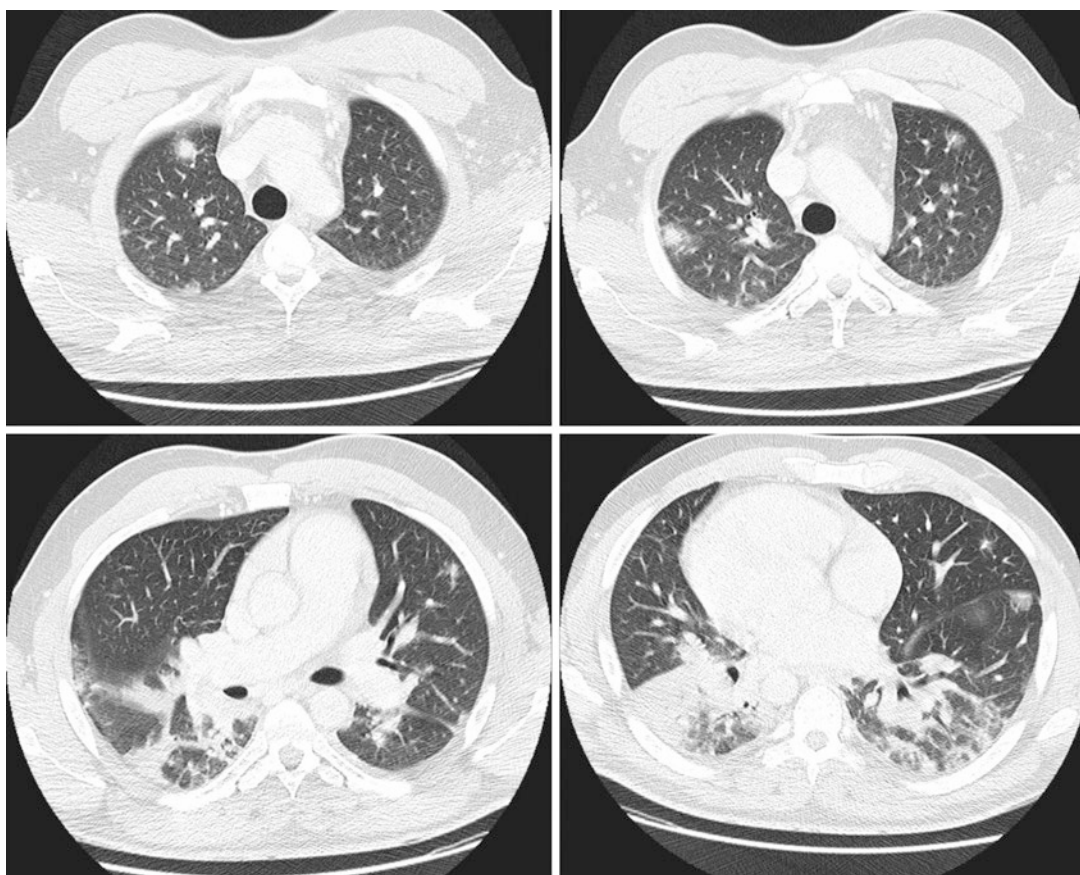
Cross-sectional computed tomography (CT) scan views showing multiple ground glass septic emboli in a 38-year-old male patient with tricuspid valve endocarditis from intravenous heroin use
